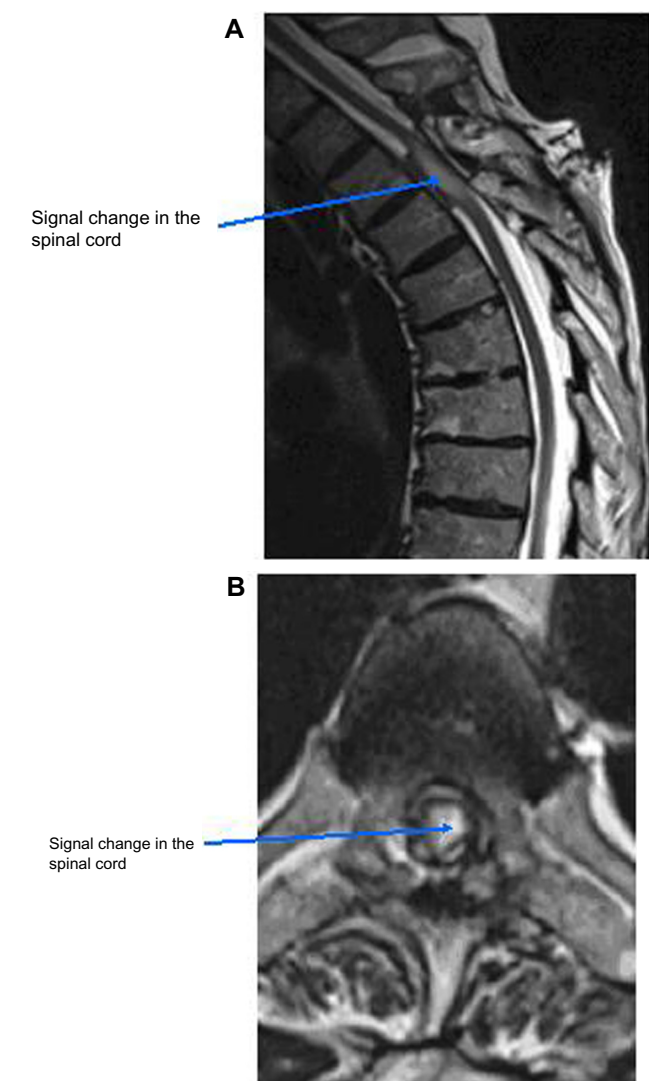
Postoperative MRI: (A) sagittal and (B) axial T2-weighted images of the thoracic spine demonstrate realignment of the spinal cord and restoration of CSF ventral to the spinal cord (case 5). At 12-months follow-up the patient was clinically improved.
